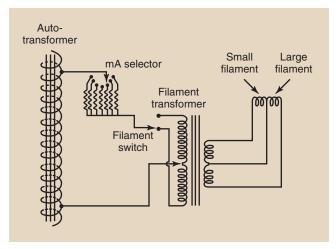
Filament circuit for dual-filament x-ray tube.
